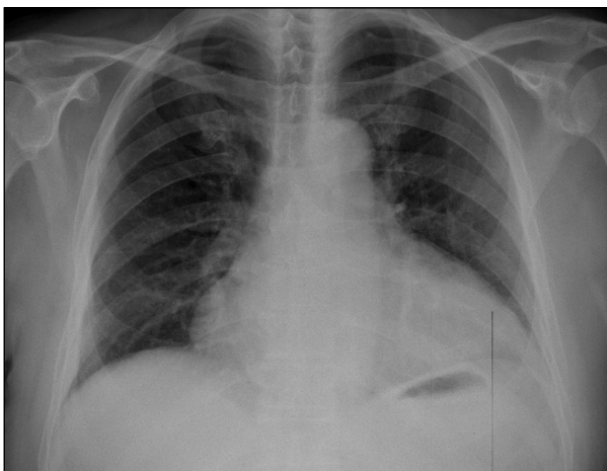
Chest x-ray (PA) in the emergency department
